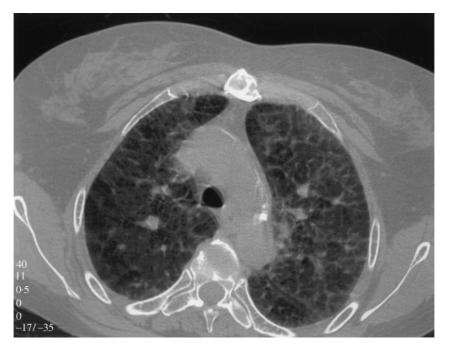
A high resolution CT scan of the chest, at the level of the aortic arch, showing diffuse bilateral interstitial lung disease.
